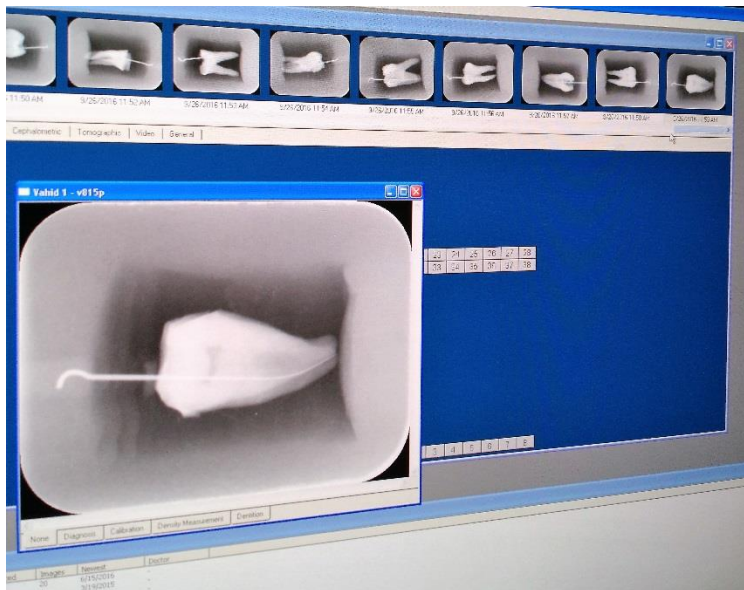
Radiography of samples to determine canal curvatures.
